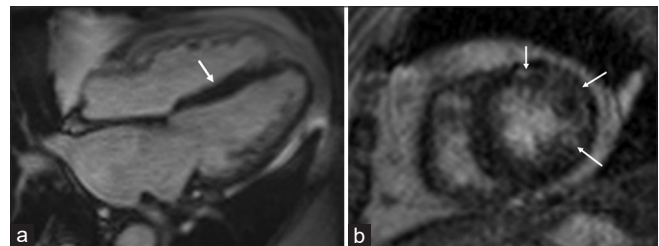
Cardiovascular MR imaging with late gadolinium enhancement (LGE). (a) Four-chamber view shows asymmetric thickening of inter-ventricular septum (white arrow). (b) Short-axis view at the mid-ventricular level shows mid-wall and subepicardial LGE in the left ventricular myocardium (white arrows).
